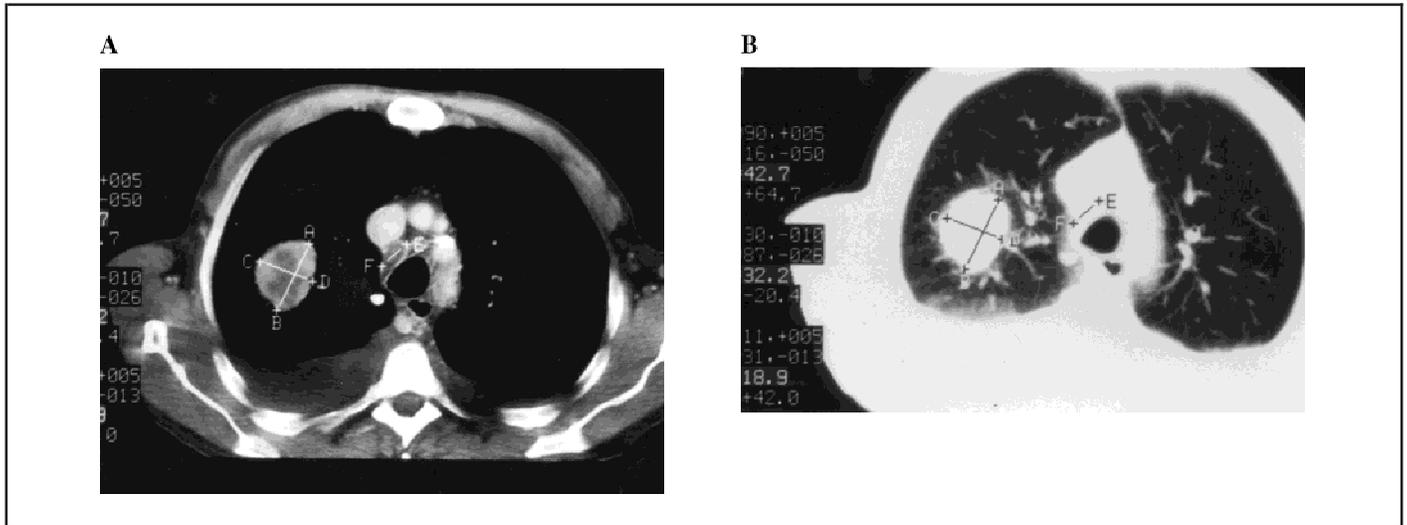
A) Computed tomography (CT) scan of the thorax at the level of the carina on “soft-tissue” windows. Two lesions have been measured with calipers. The intraparenchymal lesion has been measured bidimensionally, using the greatest diameter and the greatest perpendicular distance. Unidimensional measurements require only the greatest diameter to be measured. The anterior-carinal lymph node has been measured using unidimensional criteria. B) The same image as
